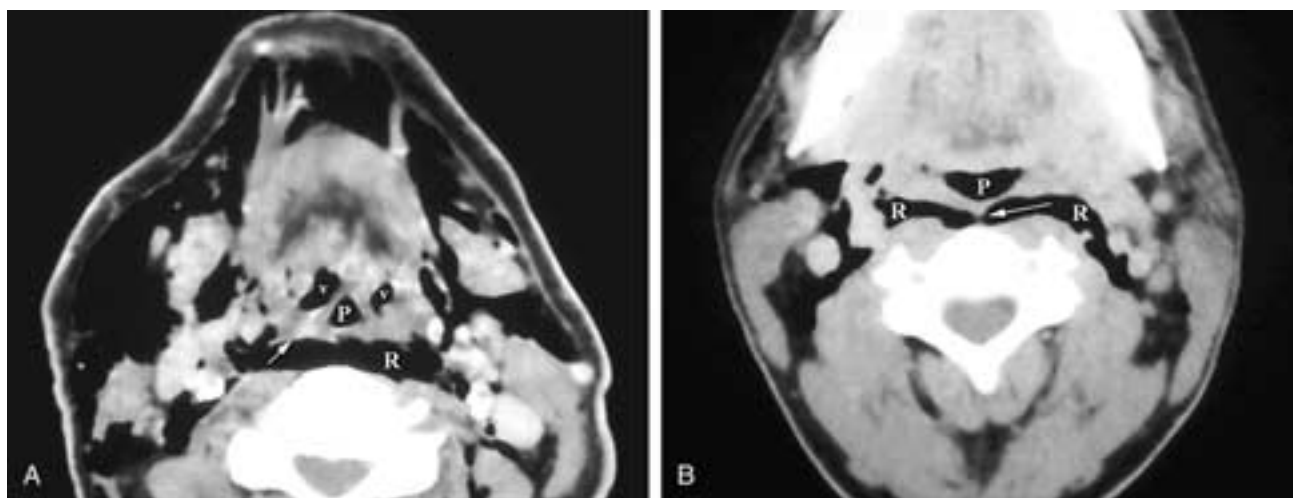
Axial contrast-enhanced CT scan (A) through the oropharynx shows air infiltrating throughout the neck in this patient who required an emergency tracheotomy. Air is seen in the retropharyngeal space (R) behind the pharyngeal airway (P) and the valleculae (v). The posterior pharyngeal constrictor muscles are seen (arrow) between these air collections. Air is also dispersed throughout the soft tissues of the neck. Axial contrast-enhanced CT scan (B) through the oropharynx of another patient shows air in the retropharyngeal space in this patient who had a tracheotomy. Note that there is a midline attachment of the visceral fascia to the alar fascia (arrow), incompletely dividing the retropharyngeal space (R) into two compartments. This type of compartmentalization occurs in nearly half of the cases (compare to A, where there is no such division of the retropharyngeal space). The pharyngeal airway is indicated by P.
